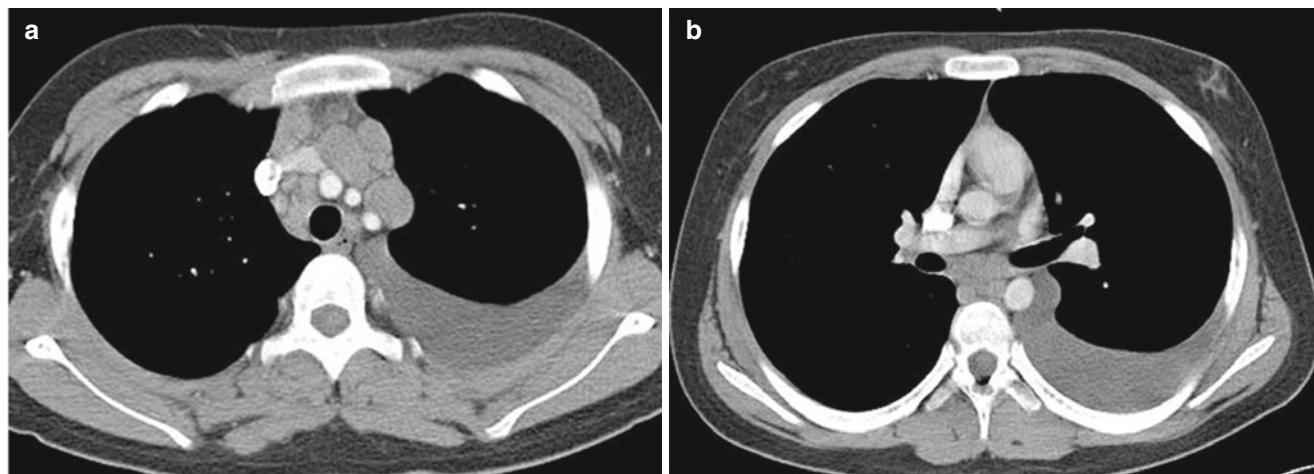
Hodgkin's disease in a 13-year-old boy with fever and weight loss. (a, b) Contrast-enhanced CT shows discretely enlarged anterior and right paratracheal nodes, lobular anterior and middle
